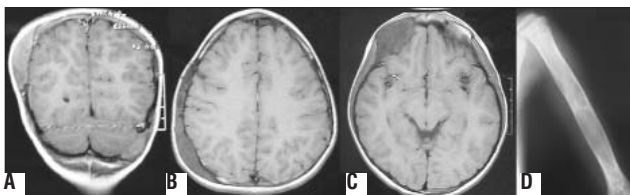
A: Coronal magnetic resonance imaging (MRI) showing extradural mass lesion at parietal area, B: Axial MRI showing fusiform expansion of skull bones extending through occipital area, C: MRI demonstrating frontal mass, D: Plain film of humerus revealing lytic lesions with ground glass appearance
